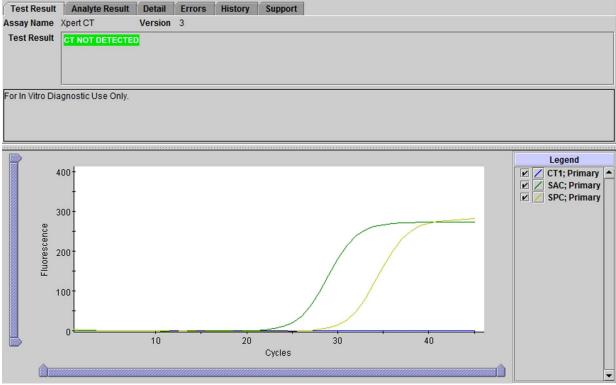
An Example of a CT NOT DETECTED Result
